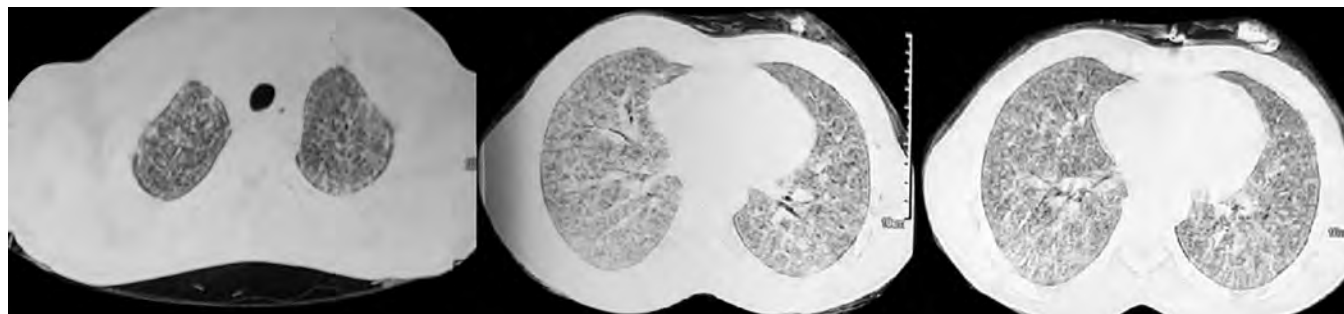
CT scan chest showing bilateral nodular lesions with areas of ground-glass haziness
